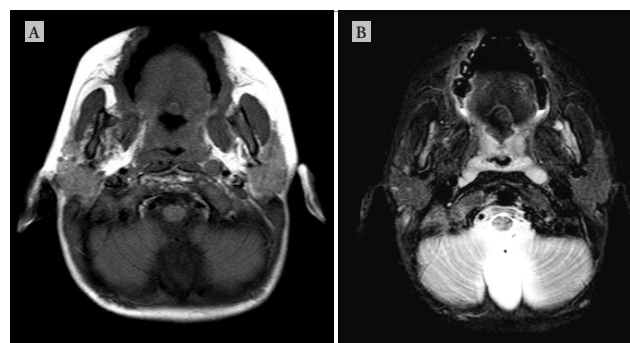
(A) T1-weighted and (B) T2-weighted MRI images of the leiomyomatous hamartoma. The intensity of the mass inner region was homogenous and similar to that of the surrounding tongue muscle.
